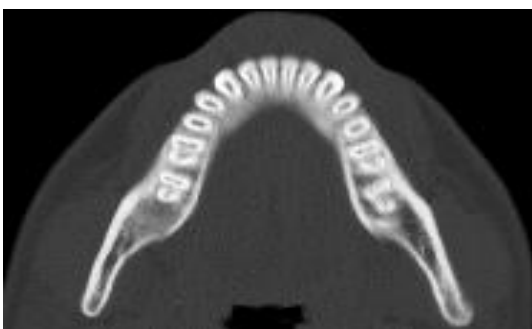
CBCT axial image shows number of pulp canal in the mandibular teeth.
